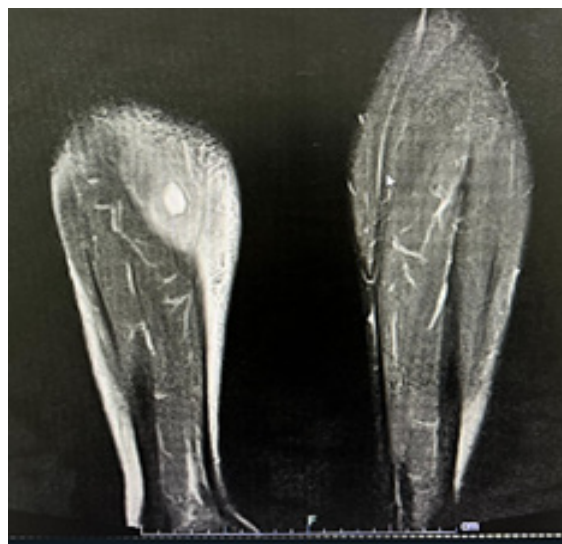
Sagittal view of MRI right lower extremity revealed diffuse hyperintense signal on T2W and TIRM within lateral gastrocnemius muscle. Focal collection of hyperintense signal on T2W and hypointense signal on T1W in lateral gastrocnemius muscle measuring 2.1 x 1.1 x 1.4 cm. The collection demonstrated hypointense rim on HEMO sequence. Diffuse enhancement noted within the lateral gastrocnemius muscle. No enhancement of the intramuscular collection in lateral gastrocnemius muscle demonstrated. There was also hyperintense signal on T2W and TIRM in medial gastrocnemius muscle, at lateral proximal aspect. Diffuse subcutaneous thickening and edema at posterior aspect of right leg. No obvious muscle retraction or complete disruption of the muscle. Visualized lower leg vessels are patent.
